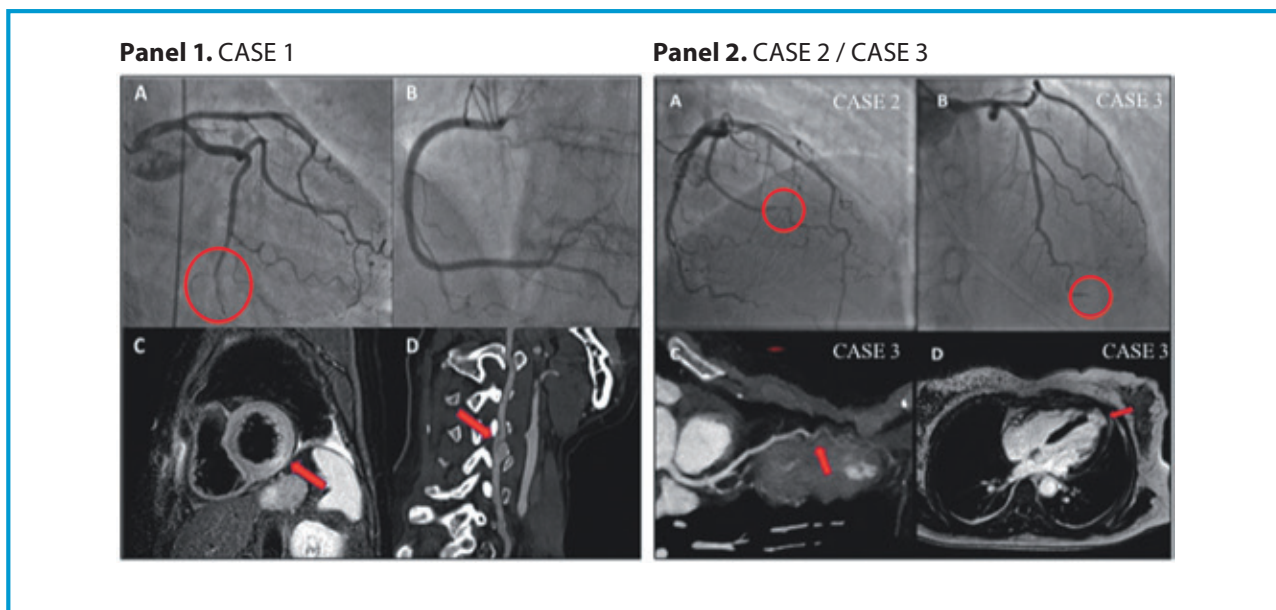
Panel 1. CASE 1. A: coronary angiogram right-caudal view: diameter mismatch in the distal left circumflex coronary artery, suspected for type 2 SCAD (red circle) and B no lesions in the right coronary artery. C: cardiac MRI showing subendocardial edema in the inferolateral left ventricular wall on T2 STIR sequences (red arrow). D: cervical angio-CT showing a dissecting aneurysm of the right vertebral artery (red arrow). Panel 2. A: CASE 2 coronary angiogram showing type 2 SCAD (red circle) or first obtuse marginal branch. B: CASE 3 coronary angiogram, showing narrowing and total occlusion of distal left anterior descending (LAD) artery (type 4 SCAD). C: computed tomography coronary angiography from the same patient confirming distal LAD dissection (red arrow) and D cardiac MRI showing transmural late gadolinium enhancement of the apical left ventricular (red arrow).
